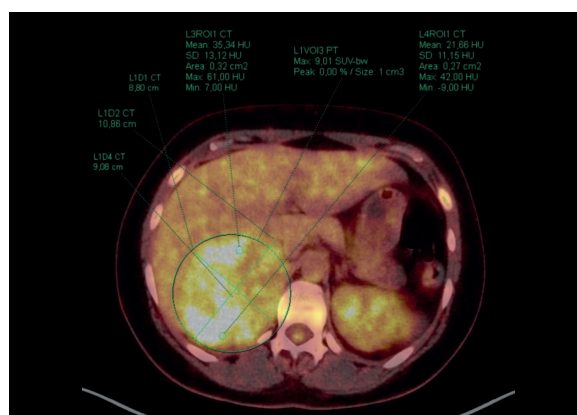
Fluorine-¹⁸F-FDG-PET-CT scan indicating high FDG uptake (SUV max 9.0), more than 3 times higher than the adjacent liver
